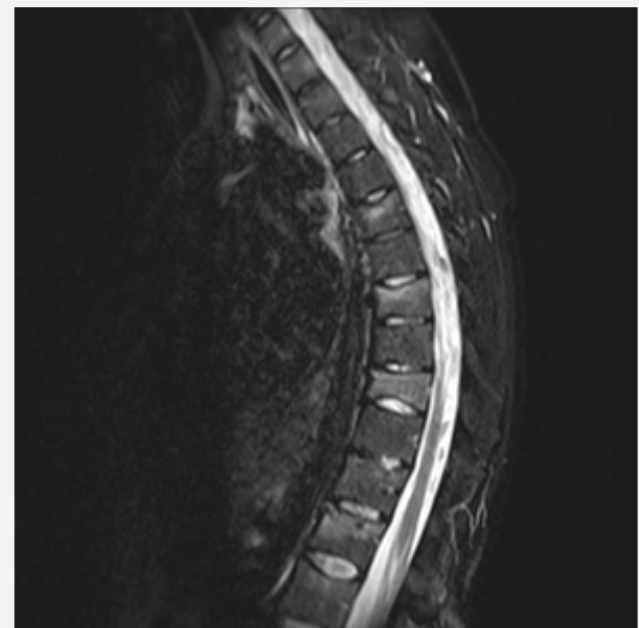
T2 sagittal magnetic resonance imaging at the beginning
